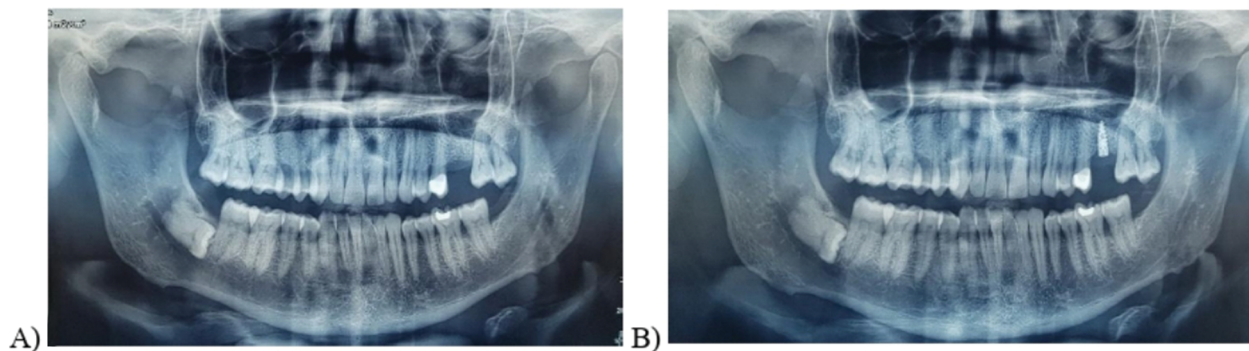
Panoramic X-ray before and after implant placement.
